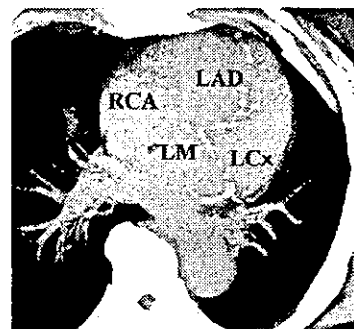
One thin slab maximum intensity projection image of the coronary arteries using routine electron-beam computed tomography. Much calcification is evident in the left main (LM), left anterior descending coronary artery (LAD), left circumflex branch (LCx), and right coronary arteries (RCA).
